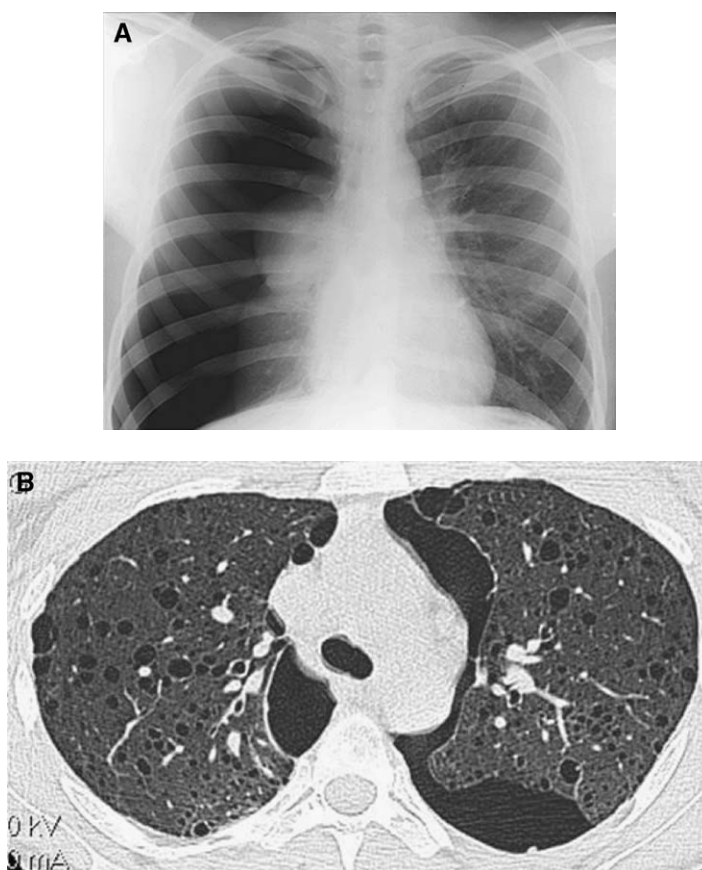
Chest radiograph (A) and CT scan (B) show pneumothorax in two patients with LAM. The pneumothorax on chest CT scan was discovered incidentally.
